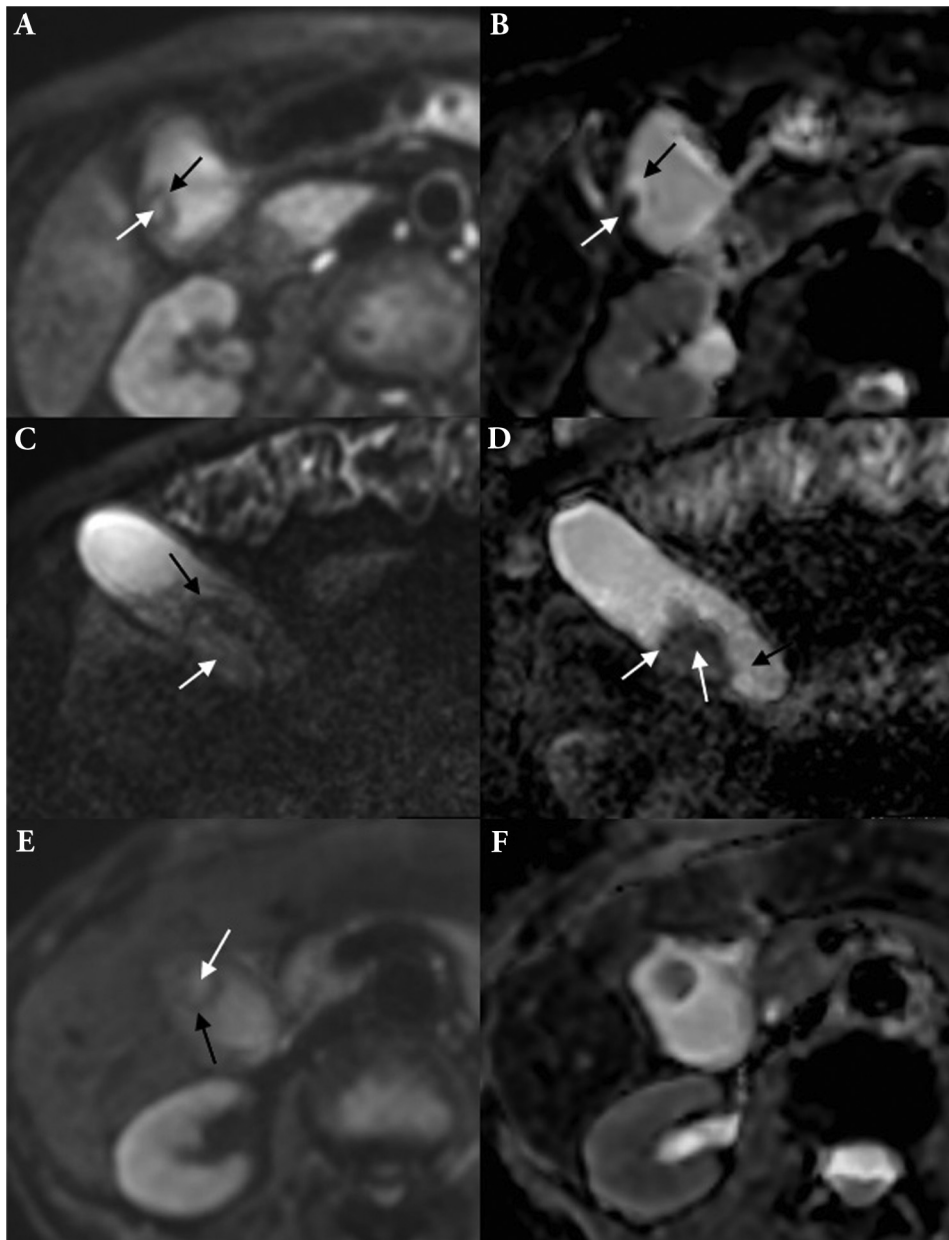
DWI and ADC pattern Three cases, left column DWI and right column ADC image (A). Adenoma showing hyperintense centre (white arrow) with hypointense ring (black arrow) on DWI (B). Adenoma showing decreased value in centre (white arrow), and a ring with increased value (black arrow) on ADC (C). Adenoma with high grade dysplasia showing hyperintense centre (white arrow) with hypointense ring (black arrow) on DWI (D). Adenoma with high grade dysplasia showing foci with decreased value (white arrow) and outer ring with increased value making the polyp seem smaller (black arrow) on ADC (E). Adenomyomatosis showing hyperintense centre (white arrow) with hypointense ring (black arrow) on DWI (F). Adenomyomatosis showing decreased value on ADC.
